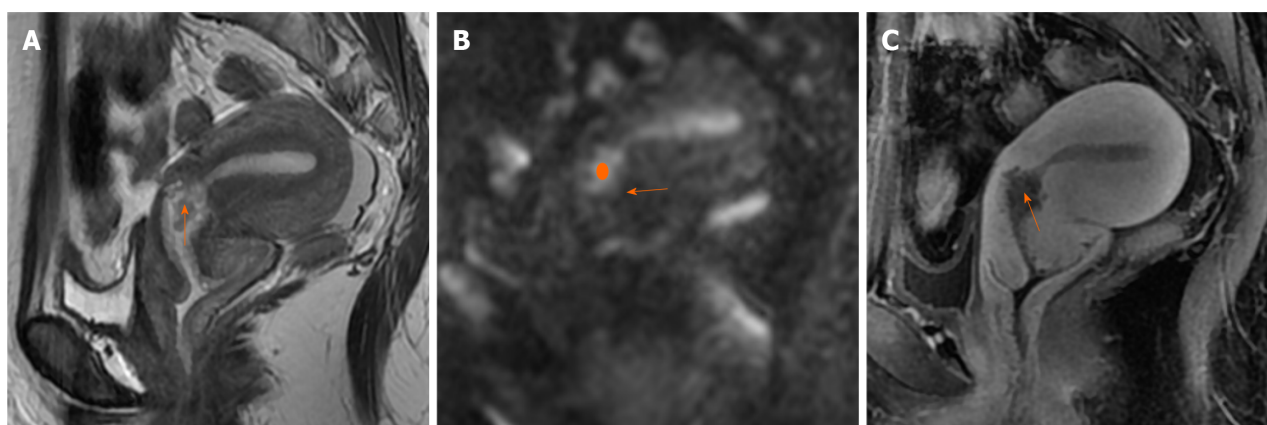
Endometrial carcinoma involving the cervical stroma in Case 2. A: On the T2WI image, polypoid nodules were observed within the mucosa of the intrauterine cervical orifice region (arrow), showing a clear boundary with the cervix; B: On the DWI image, the nodule exhibited a slightly hyperintense signal (circle), while the endocervical stroma displayed a hypointense signal (arrow); C: On the enhanced image, the nodule was marginally enhanced and distinctly separate from the endocervical stroma (arrow).
